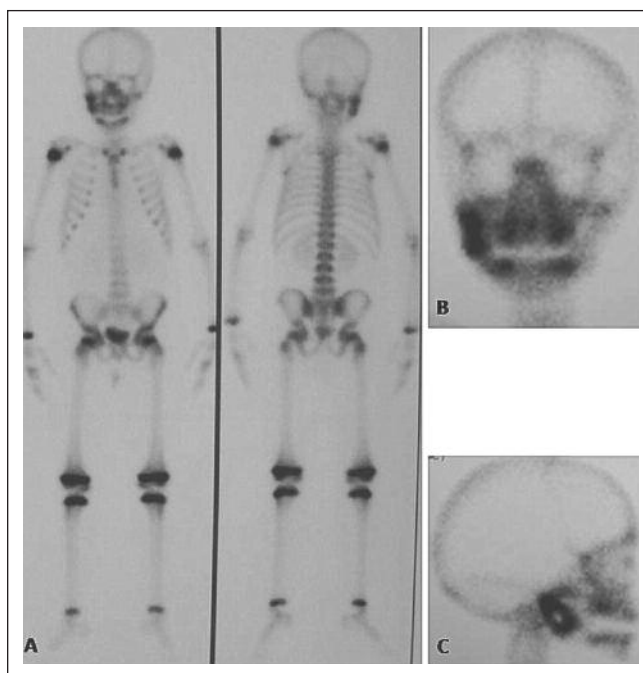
Bone scintigraphy showing an area of radioisotope hyperuptake in the right mandibular ramus in the absence of other skeletal involvement.
